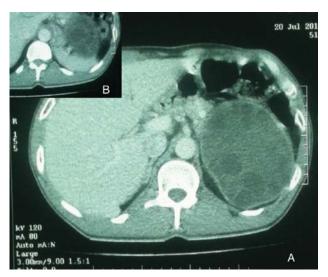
(A) Computed tomography of the abdomen demonstrating a large cystic lesion of left anterior renal cortex with a well-defined wall and daughter cysts within, (B) Computed tomography scan showing the association between the cyst and the kidney.
